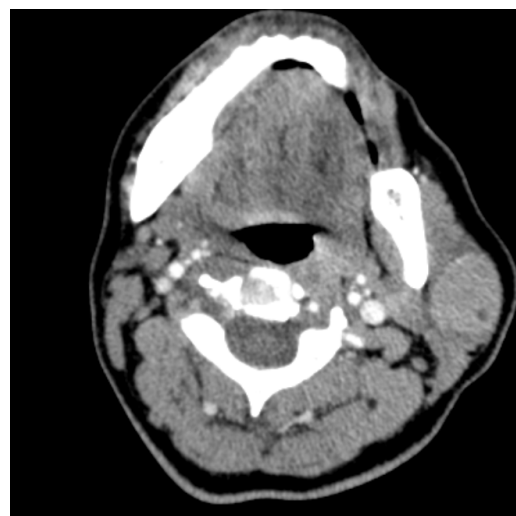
CT image of the mass in the left parotid
